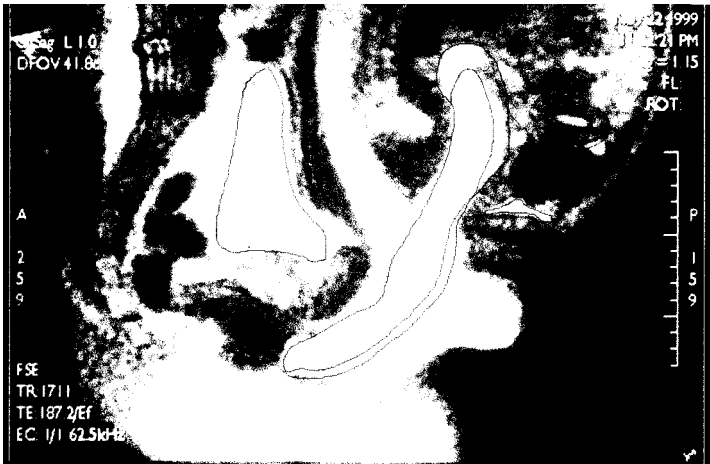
MRI third session (rear entry position)
